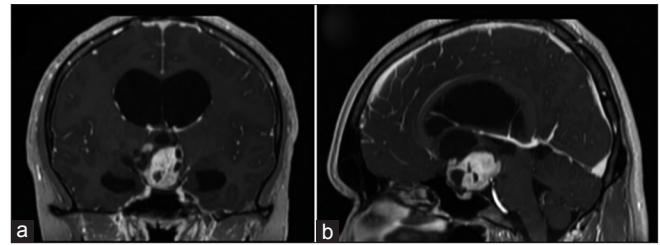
Contrast-enhanced T1-weighted MR images, coronal (a) and sagittal (b) views, show a suprasellar mass lesion with cystic components
